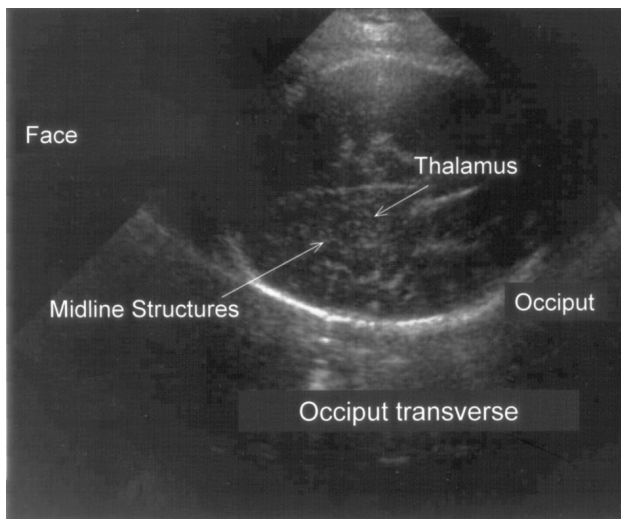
Ultrasound image of fetus in the occiput transverse position.
